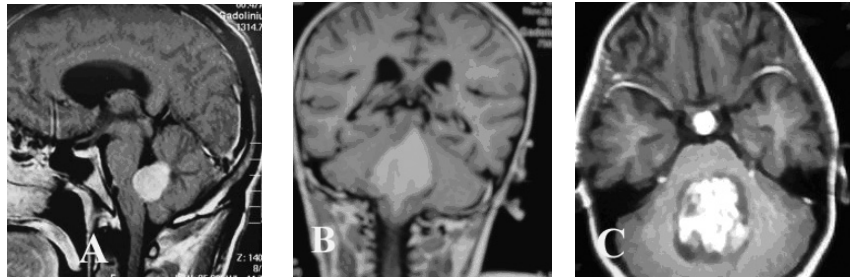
MRI brain T1 with gadolinium sagittal, coronal and axial cuts shows: A: small midline posterior fossa intra-axial enhancing lesion above the foramen magnum. B: Large posterior fossa intra-axial enhancing lesion extending from aqueduct to foramen magnum. C: Large posterior fossa intra-axial enhancing lesion with suprasellar seeding.
